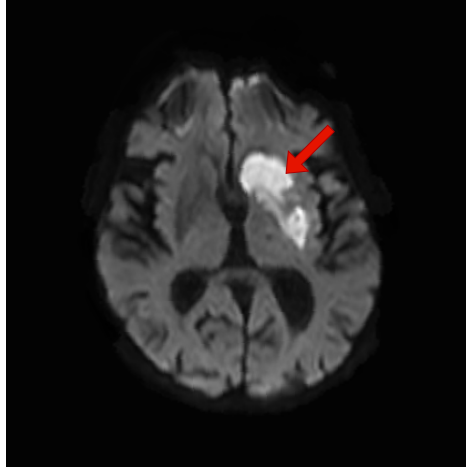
Example of a DWI scan from a subject in our dataset. In this patient, the FIA is located on the left side in the vascular territory of the middle cerebral artery (pointed by a red arrow).
